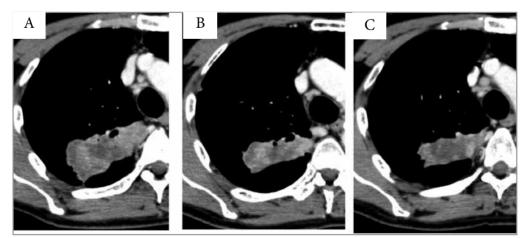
Chest CT scan before the nivolumab therapy (A), chest CT scan at 9 weeks (B), and chest CT scan at 22 weeks after the initiation of the therapy (C).
